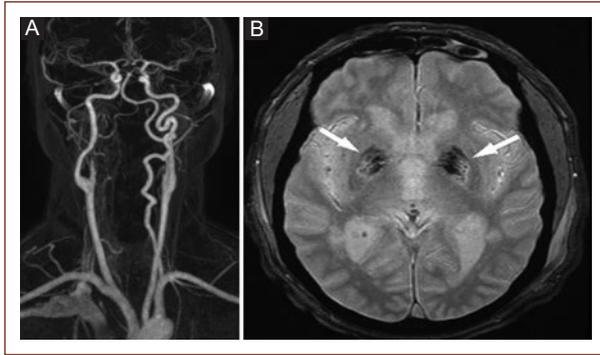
A: 3D coronal reconstruction of supra-aortic and intracerebral vessels (B) T2 brain MRI with microhemorrhages in both pale globe.
